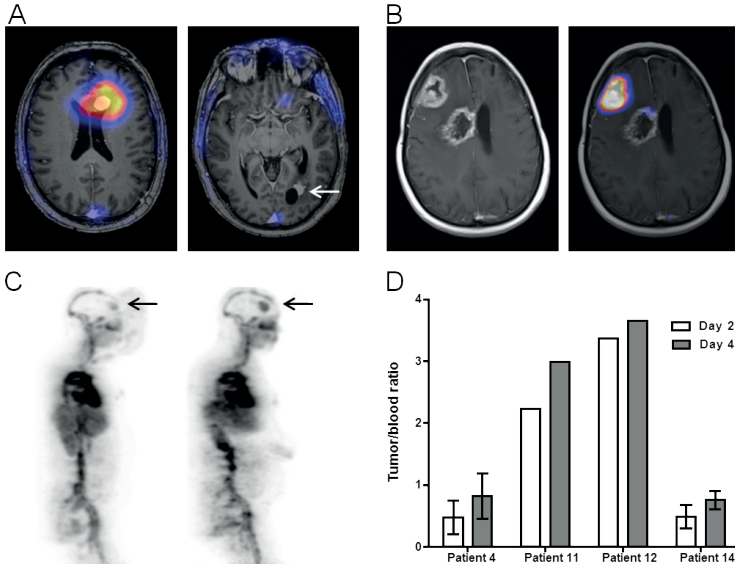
A: Fused MRI and PET scan of a patient with 2 contrast enhancing lesions. High uptake visible in the frontal lesion (left image). No uptake visible on PET scan in occipital lesion (right image, arrow) that was previously irradiated. B: MRI and fused MRI/PET images of a patient with 2 contrast enhancing lesions. The SUV_{max} in the progressive right frontal lesion was 5.5. The SUV_{max} in the previously irradiated lesion paraventricular right was 2.1. C: Whole body PET scan on day 2 (left) and day 4 (right) with increase of SUV_{max} in frontal brain lesion (black arrows) from 4.0 to 5.5. Tumor to blood ratio increased from 0.8 to 1.2. D: Tumor to blood ratios on ⁸⁹Zr-fresolimumab PET in 4 patients on day 2 and day 4 after injection.
